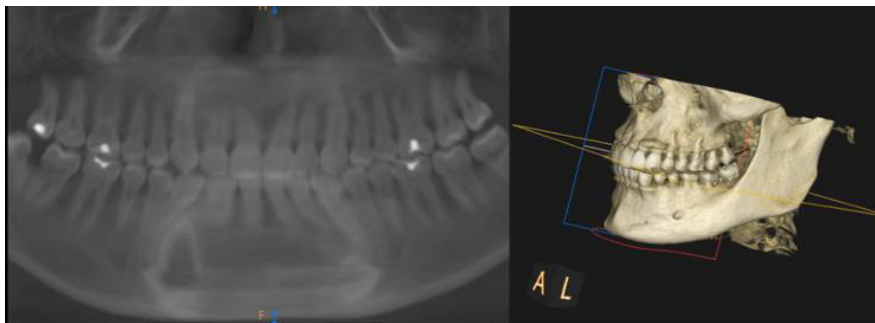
Final orthopantomography and 3D reconstruction.*
